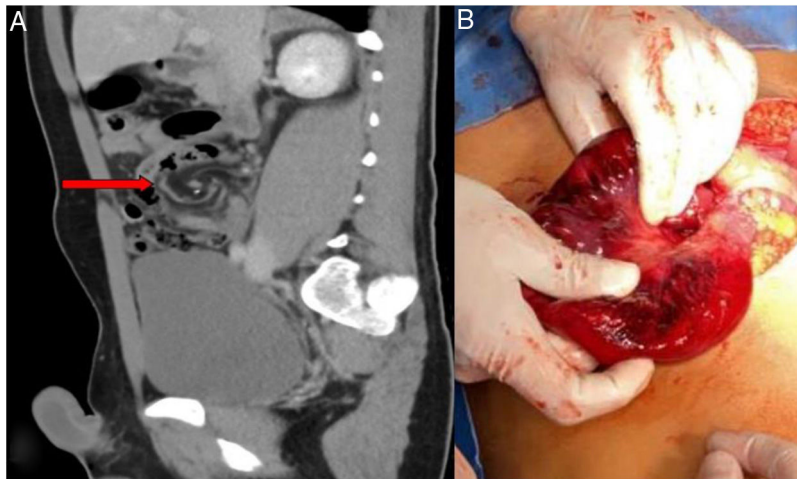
(A) Sagittal view of the CT scan. The red arrow indicates the whirlpool sign in the mesentery of the terminal ileum. (B) Intraoperative image showing bowel ischemia.
